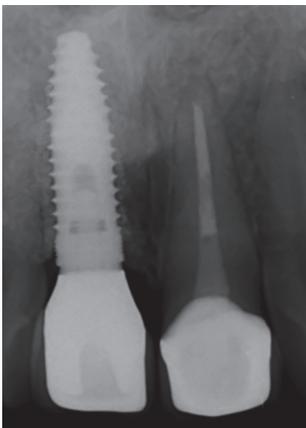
and 4B one-year post-op. Fig 4C shows radiographic assessment one-year post-op. No change in position of attached gingiva and zenith.
